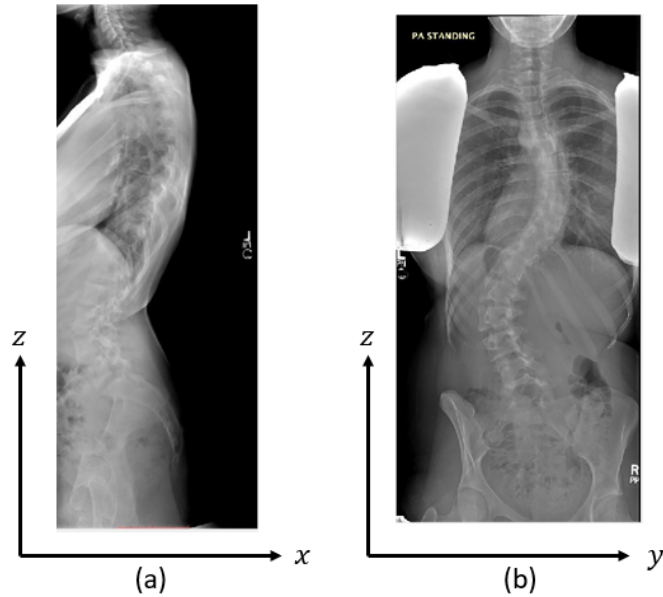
(a) Lateral (LAT) and (b) Anteroposterior (AP) view of the image obtained from X-ray data.
